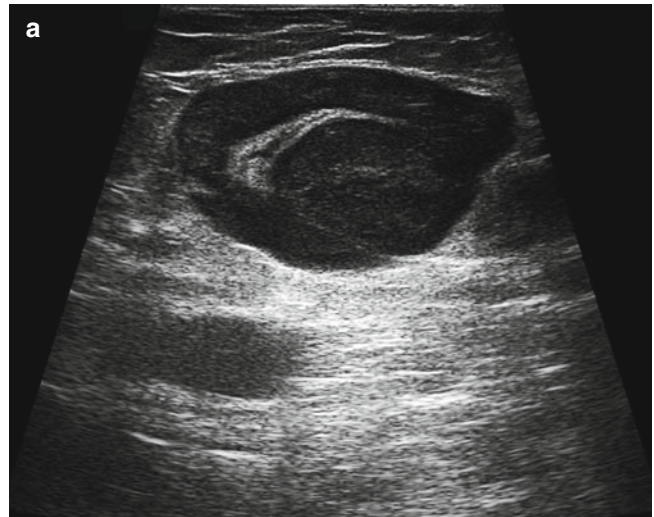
Lymph-node metastasis. Diffuse thickening of the nodal cortex (a). Despite this, the hilar vascularization is preserved on the directional power Doppler image (b), with no capsular vessel evident
